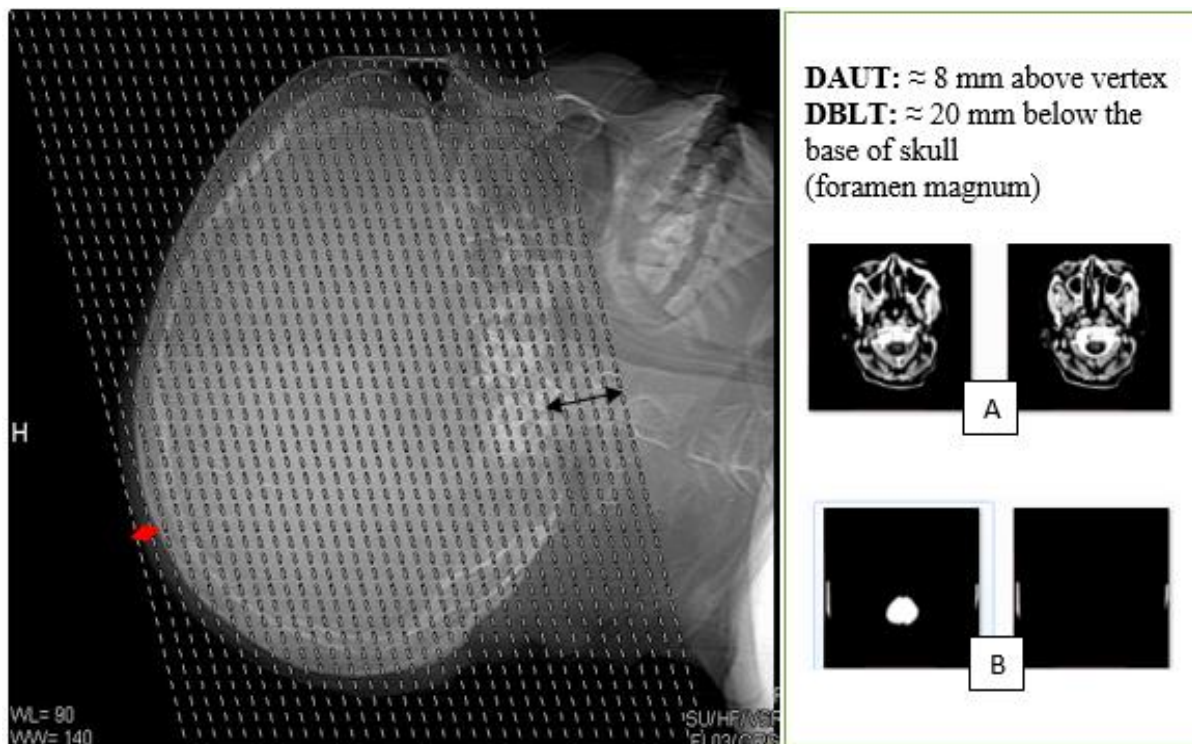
A typical scan coverage (grid areas) for a “Full range” CVA CT. Plate A shows the last two slices from the base of the skull (caudally) and Plate B shows the last two slices cranially which contain no information for CVA diagnosis. The red arrow shows a typical mean DAUT and the black arrow shows a typical mean DBLT used across the facilities.
